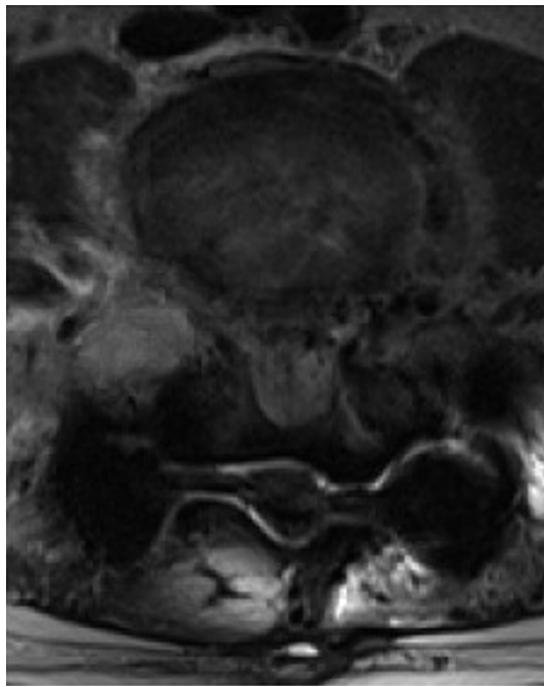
Axial T2 magnetic resonance imaging demonstrates lesion extension into the ventral epidural space causing severe central canal stenosis at L5 and S1.
